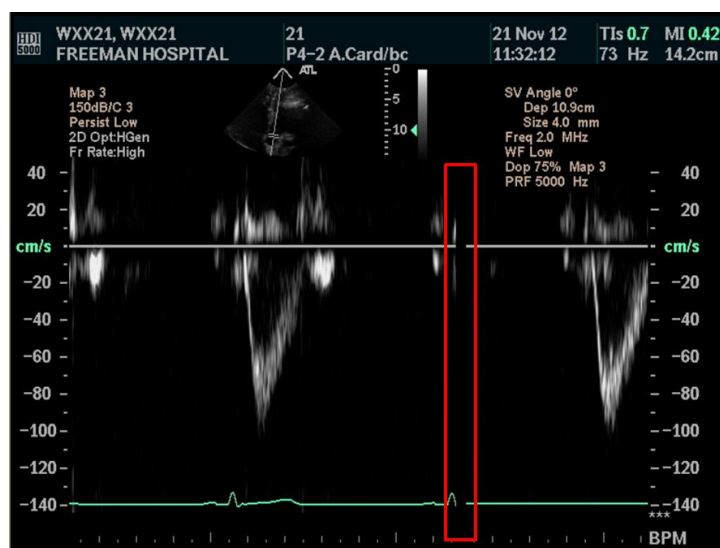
An example of a Doppler DICOM image loaded by MATLAB. Approximately 80 frames are shown on this screen. The entry of new frames was located at the left side of a raster moving from left to the right (indicated by the red box). When the farthest right side was reached, the raster was swept to the left side.
